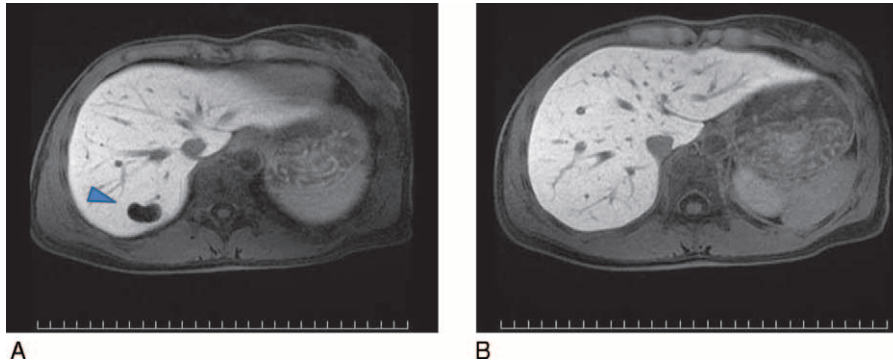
Magnetic resonance images from after the completion of bevacizumab/paclitaxel/carboplatin therapy in 2014. Metastatic lesions were replaced by visible cavitations in S7 (arrows indicate cavitations; A) and subsequently disappeared (B).
